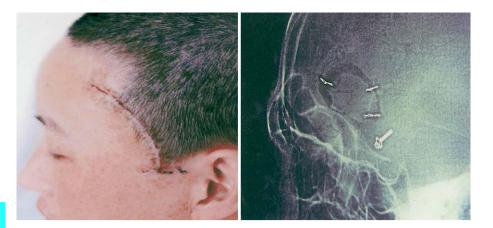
The skin incision (left) and postoperative X-ray (right) showing that the bone flap was very small.
